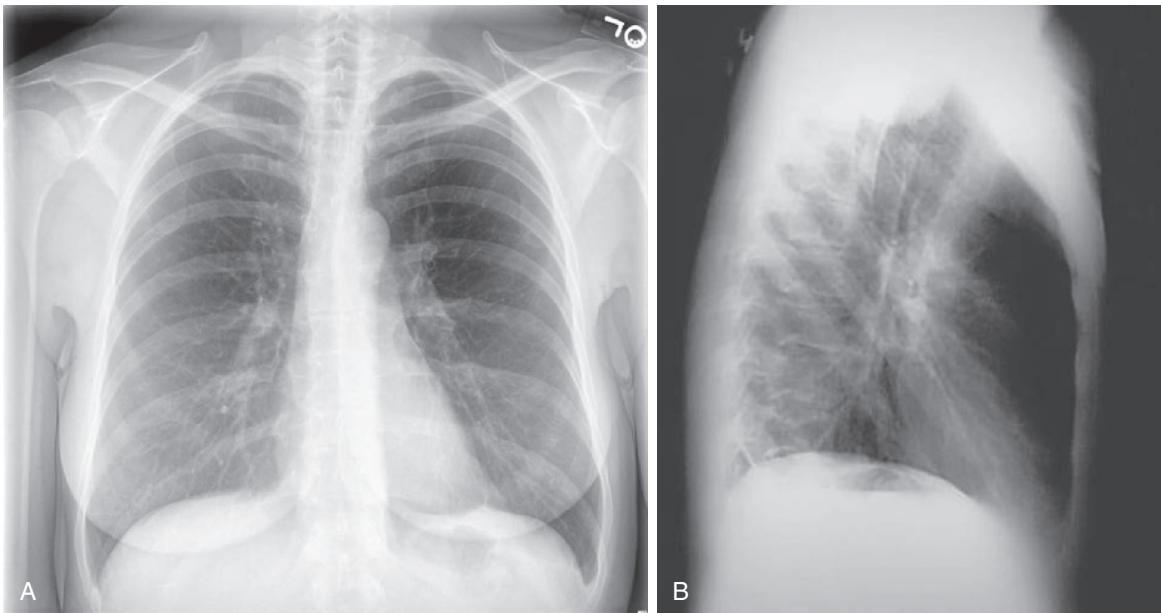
(A) Normal erect posteroanterior chest radiograph. (B) Normal erect lateral chest radiograph. (From Northcentral Technical College, Wausau, Wisconsin.)
